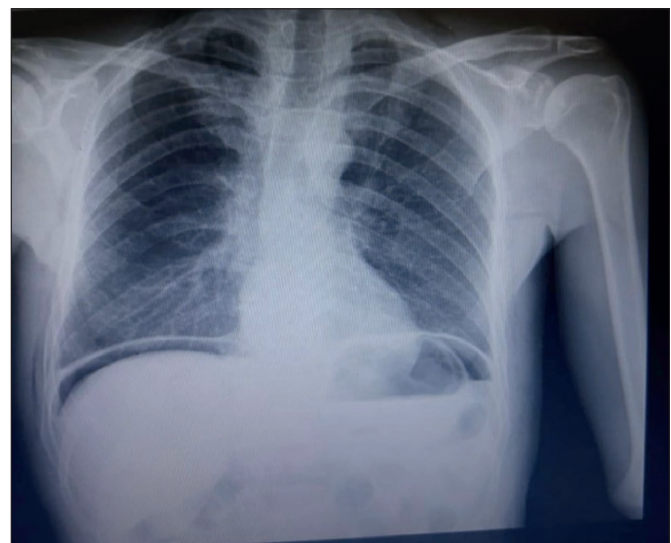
Postoperative day-2 radiograph (Subcutaneous emphysema resolved).
